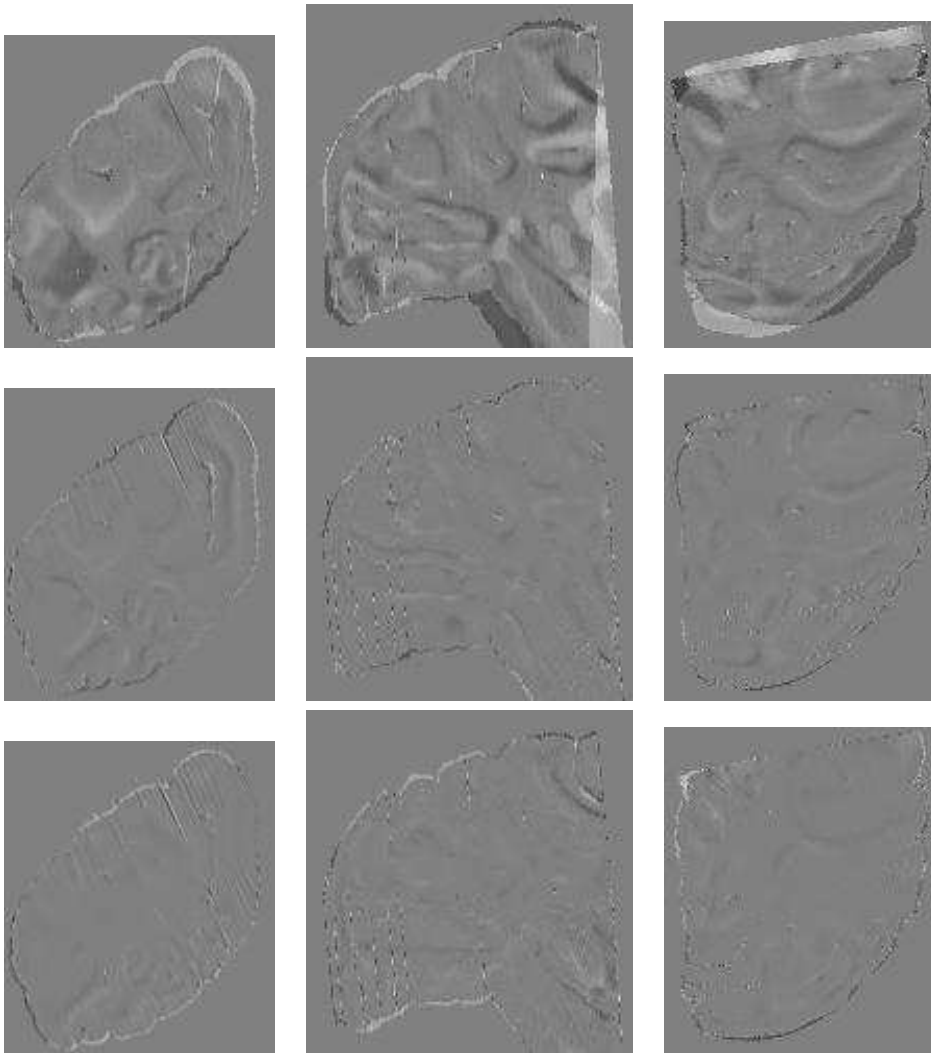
Difference images between the successive autoradiographic volumes (AV) registered against the MR image. First row: AV after loop #1 minus first reconstructed AV. Second row: AV after loop #2 minus AV after loop #1. Third row: AV after loop #3 minus AV after loop #2.
